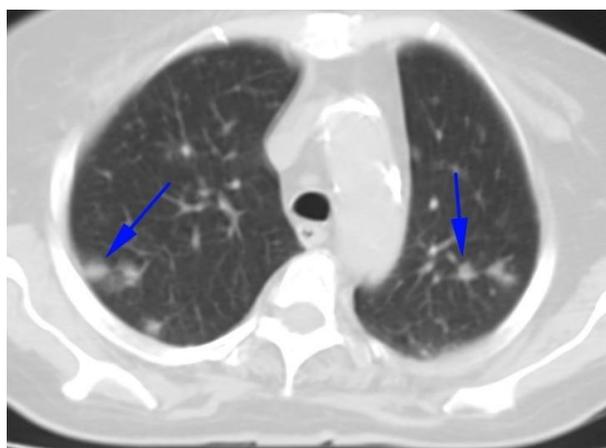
Multiple septic pulmonary embolism image at thorax CT on admission.
